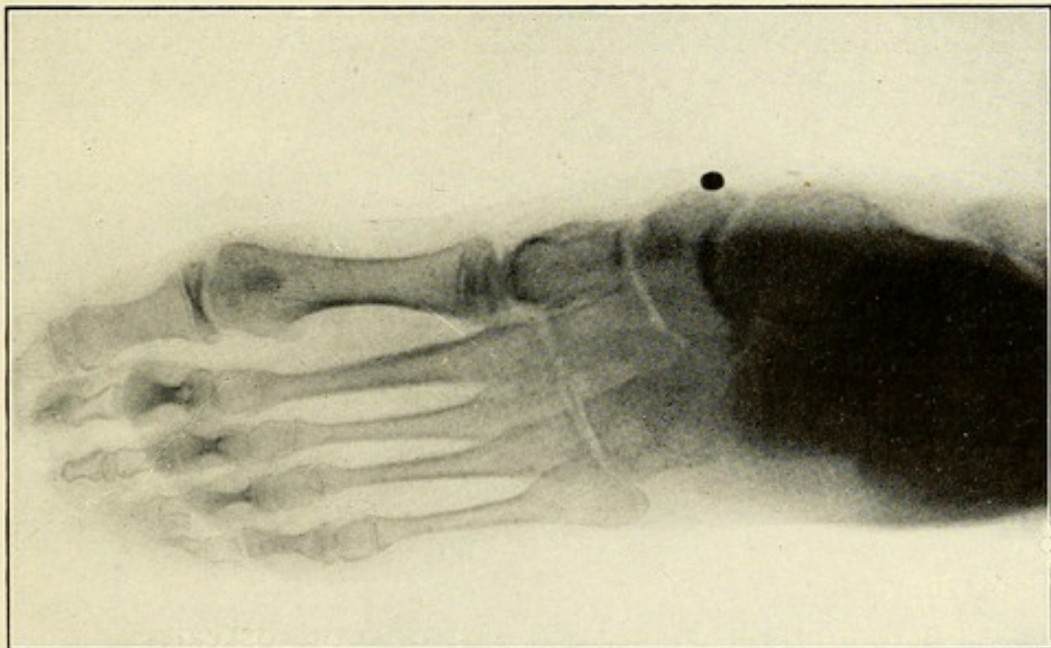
Roentgen picture of Case VII. Metal mark shows position
